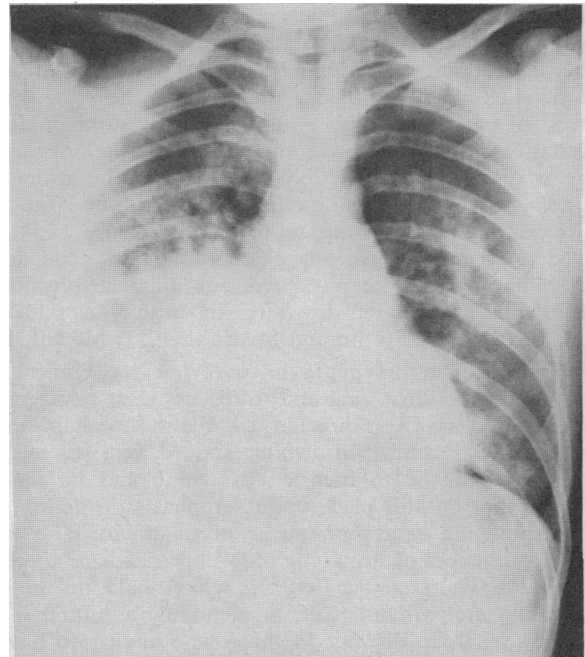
Case 1. Chest x-ray appearances 17½ hours after admission.
